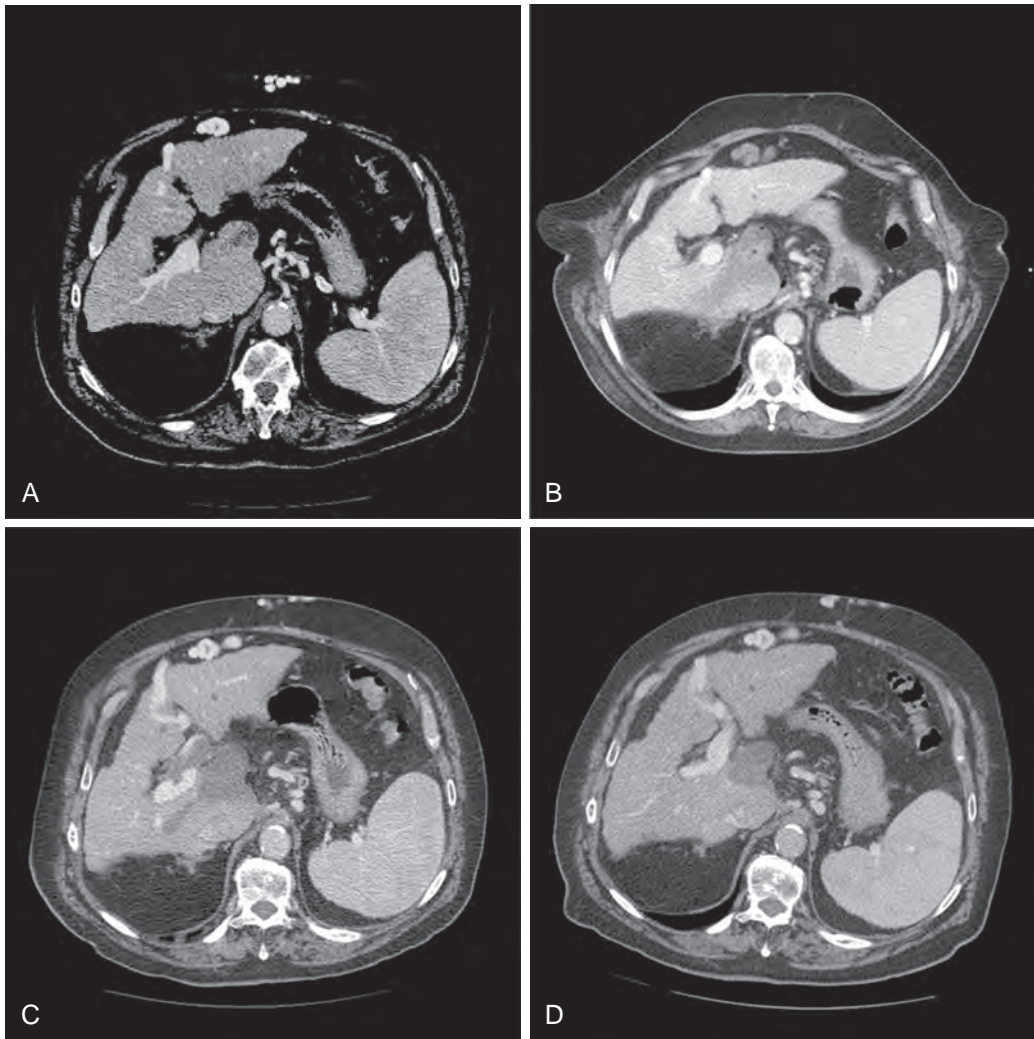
Portal vein thrombosis after microwave ablation. A. Portal venous phase CT demonstrates an exophytic lesion arising from the caudate lobe that met imaging criteria for HCC, which underwent percutaneous microwave ablation. B. Subsequent CT demonstrates the immediate postablation appearance. C. CT performed at 1 month after the procedure demonstrates nonocclusive portal venous thrombus, a complication of the ablation procedure. D. The patient was prescribed warfarin and the thrombus resolved, as seen on the CT performed at 1 year after the procedure.
